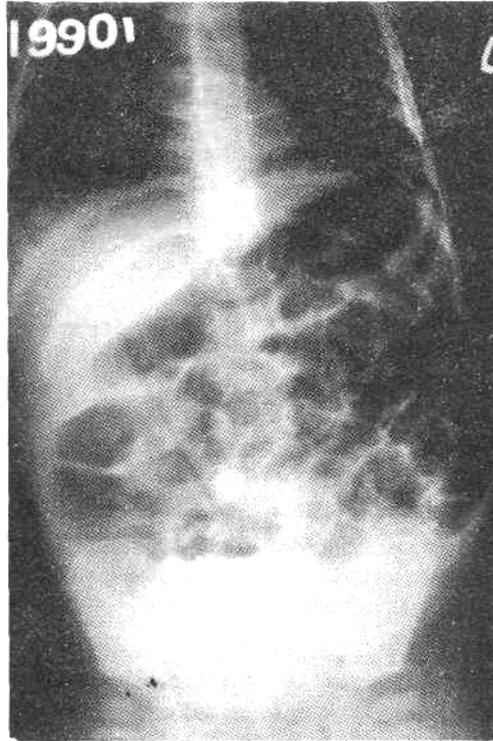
Roentgenogram showing bulging on the left side.
